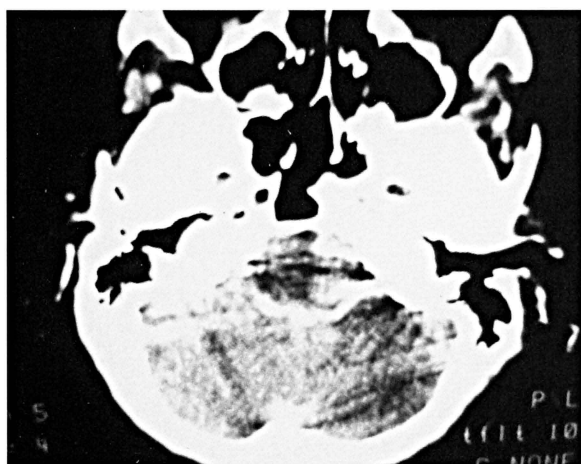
A CT scan on admission showing posterior fossa subarachnoid haemorrhage with clot in the left cerebello medullary cistern.
